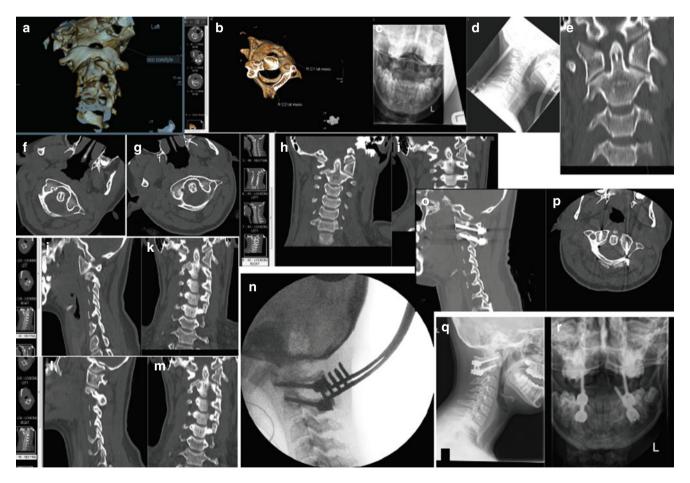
Atlanto-axial rotatory fixation. CT reconstructions demonstrating rotatory subluxation of C1 on (a) C0 and (b) C2 at initial presentation following 6-weeks of torticollis. After 6-weeks of no improvement in a cervical collar, reduction was achieved by traction and placement in a halo. (c) AP open mouth and (d) lateral C-spine radiographs with (e) coronal CT and (f) axial CT to the left then (g) right demonstrated marked improvement after 10 days traction. Check
